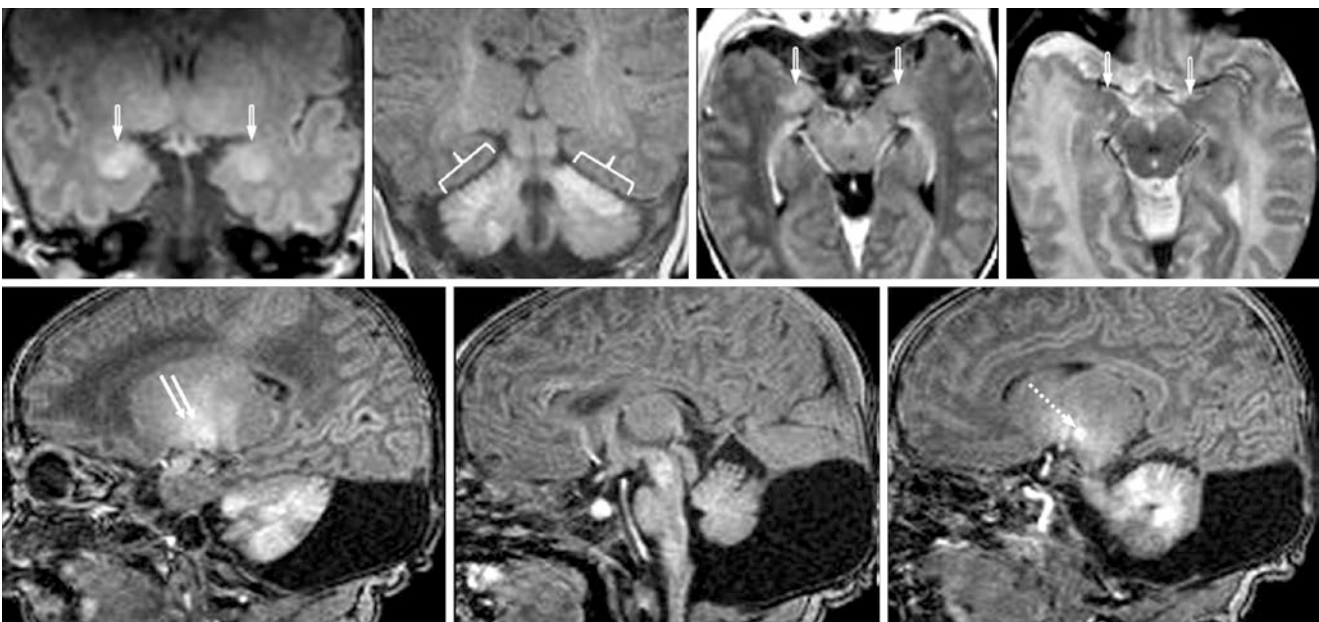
Comparison case of neurocutaneous melanosis. A 3-day-old term neonate with seizures (without hypoxia) had a 1.5T MRI that showed bright signal within the amygdalae (*beveled arrows*) on coronal GE T1WI (*top left and left middle*) and postcontrast T1WI (*top, right middle*), being dark on SE T2WI (*top right*). There was also T1-bright
